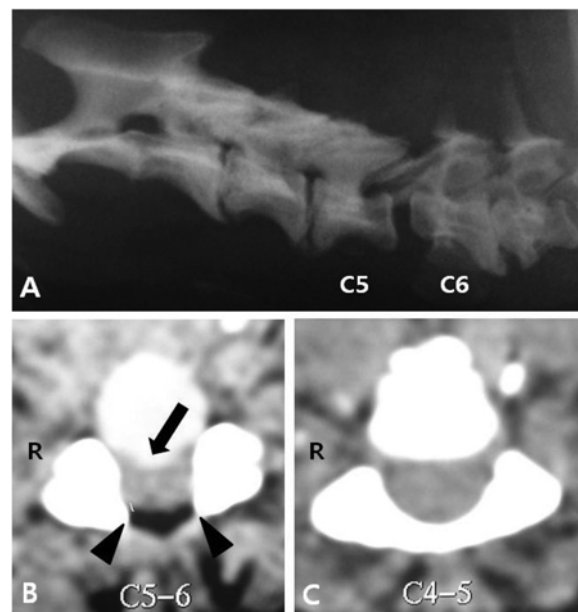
Cervical radiograph and CT imaging of a 9-year-old neutered female Pekingese with neck pain and tetraparesis. The lateral survey radiograph (A) shows the abnormal alignment of C5-C6. Transverse CT image at the level of the intervertebral space of C5-C6 (B) shows the ventral compression of the spinal cord by disk protrusion (arrow) and highlighting the ventrally compressed spinal cord, which has not dorsally deviated by ventral disk protrusion. This is thought because of the dorsolateral compression of the spinal cord (arrow head) by secondary soft tissue changes. Transverse CT image at C4-5 (C) shows the normal appearance of the spinal cord.
